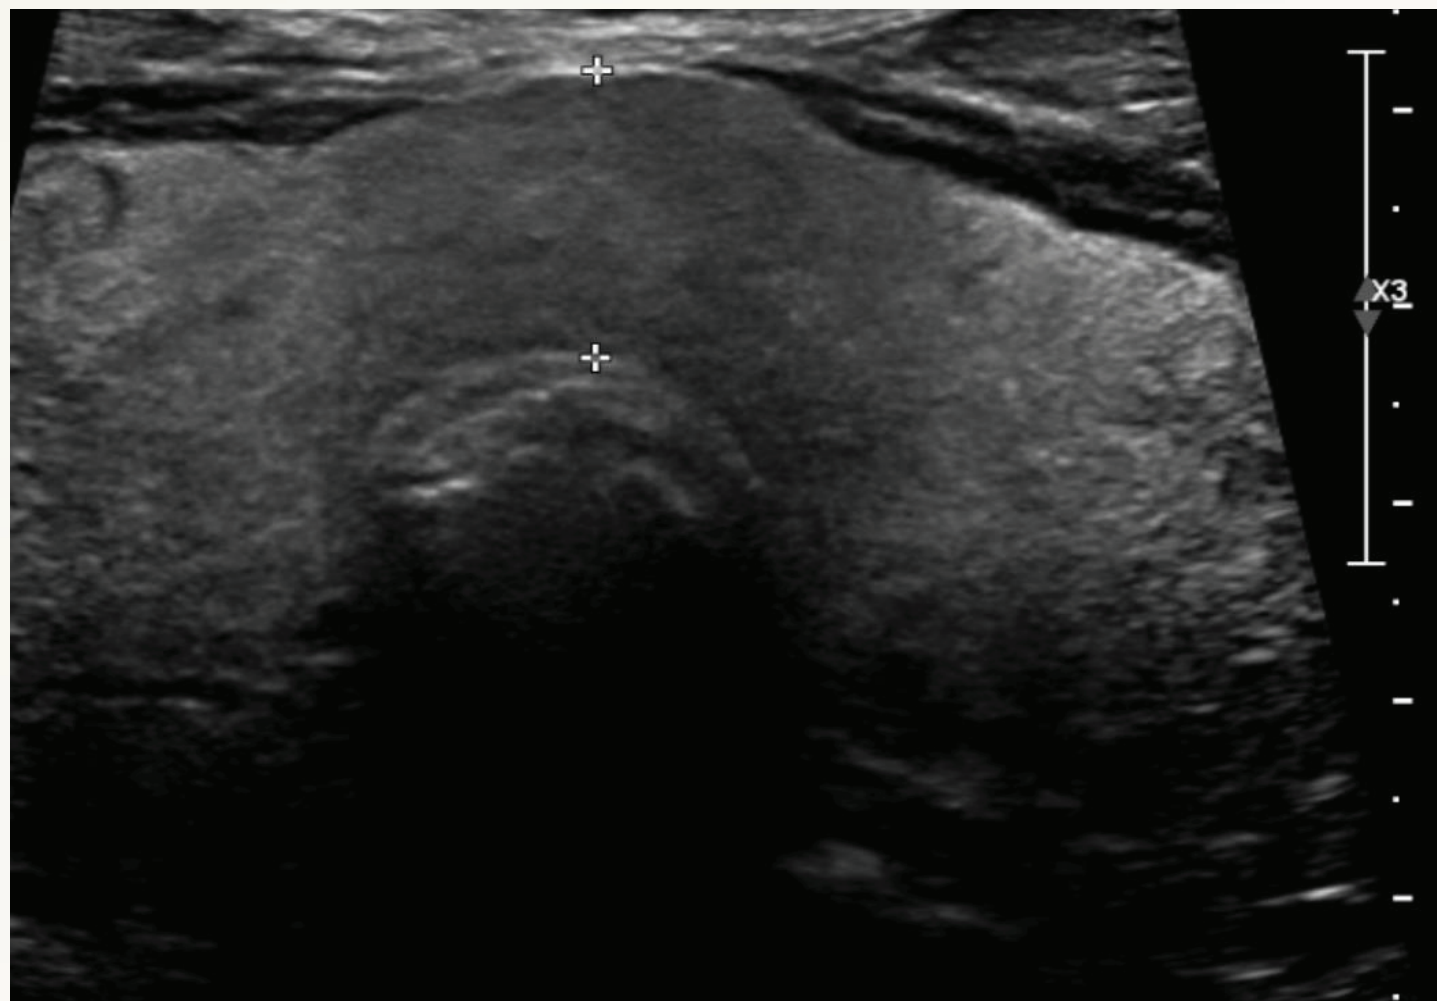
Thyroid ultrasound image with generalized thyromegaly and enlarged isthmus
